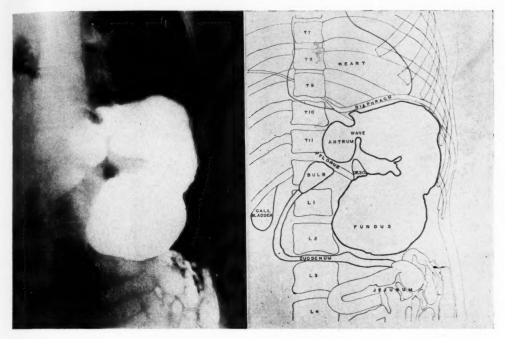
Radiograph of the filled stomach, patient prone.
